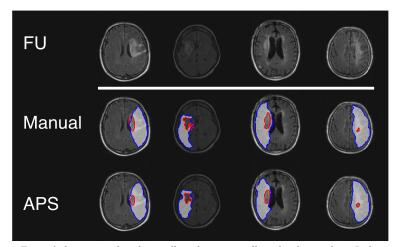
shows examples of manually and automatically outlined penumbras. Red contour is DWI lesion, blue contour is PWI lesion and the white-hatched area is the penumbra.
